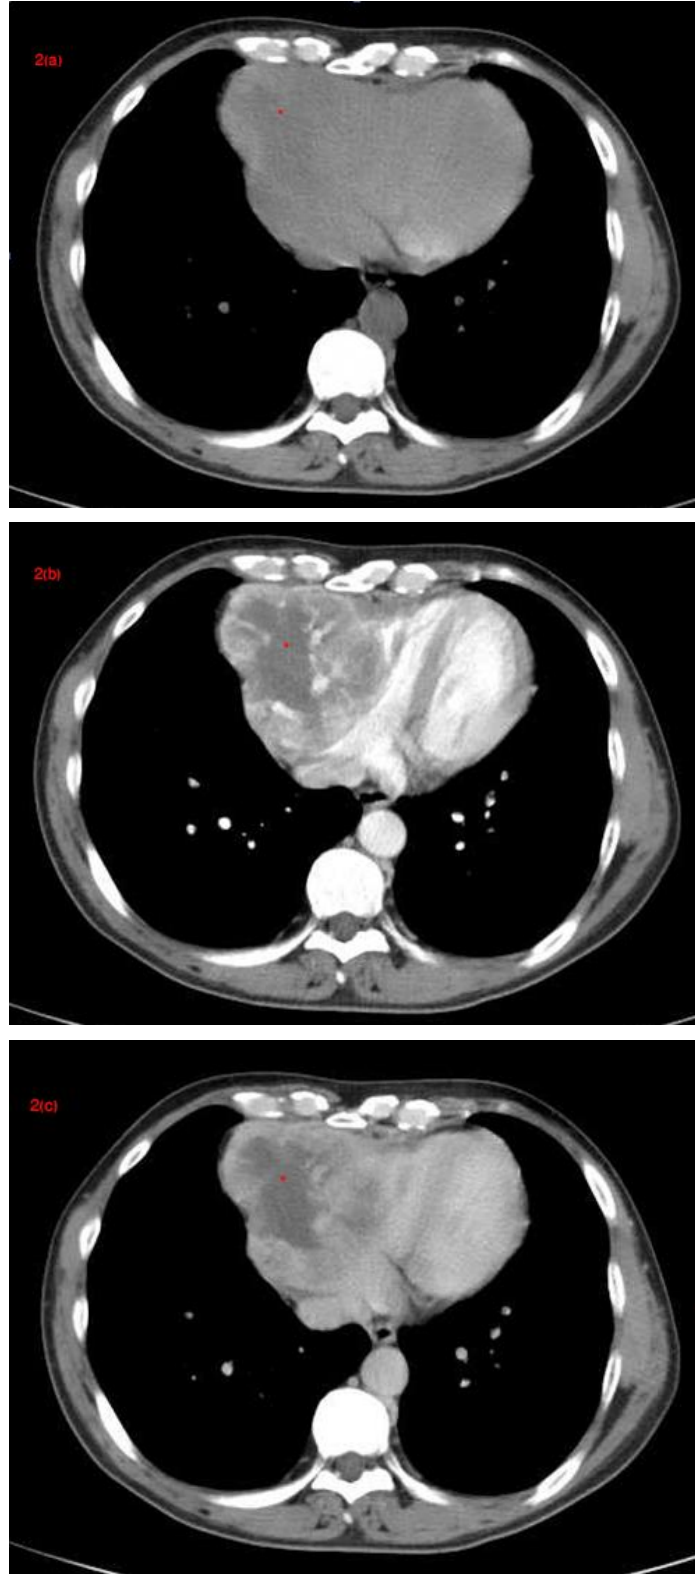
CT plain scan showed irregular mass on the right side of anterior mediastinum with uneven density, obvious uneven enhancement in arterial phase and continuous enhancement in venous phase.
